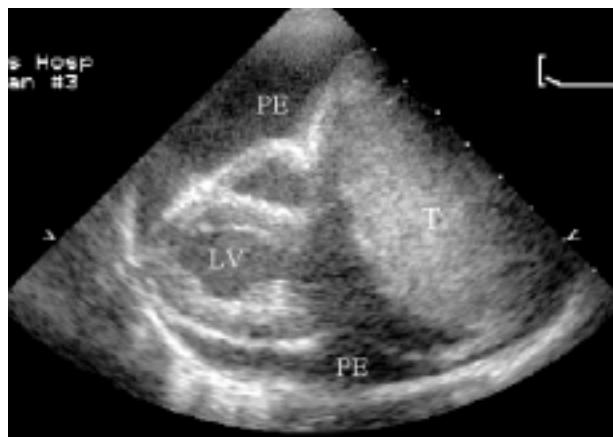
Two-dimensional echocardiogram in parasternal long-axis view, showing a large mass (T) at the base of the heart with global pericardial effusion (PE). LV = left ventricle.
